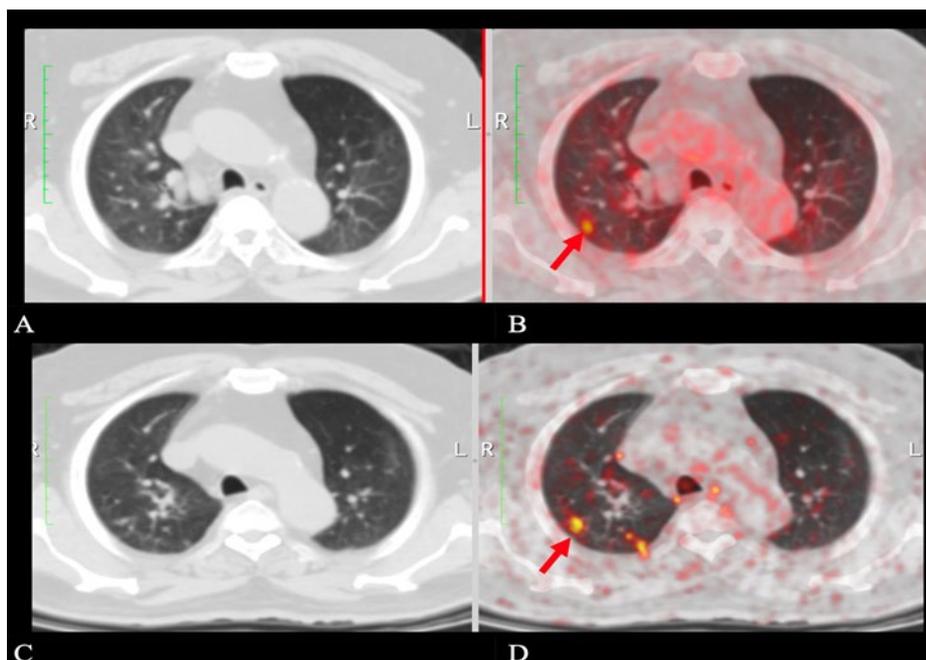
Patient post external beam radiotherapy. Ga-68 PSMA PET/CT at 1 h p.i.(A [low dose CT at 1 h p.i.] and B [fusion PE/CT at 1 h p.i.] and at 3 h p.i. (C [low dose CT at 3 h p.i.] and D [fusion PET/CT at 3 h p.i.]). Red arrows point to PSMA uptake at the right upper lobe suspicious of prostate cancer recurrence at 1 h p.i. with increasing uptake and contrast in late scans (SUVmax 2.9 at 1 h p.i. and 4.8 at 3 h p.i.).
